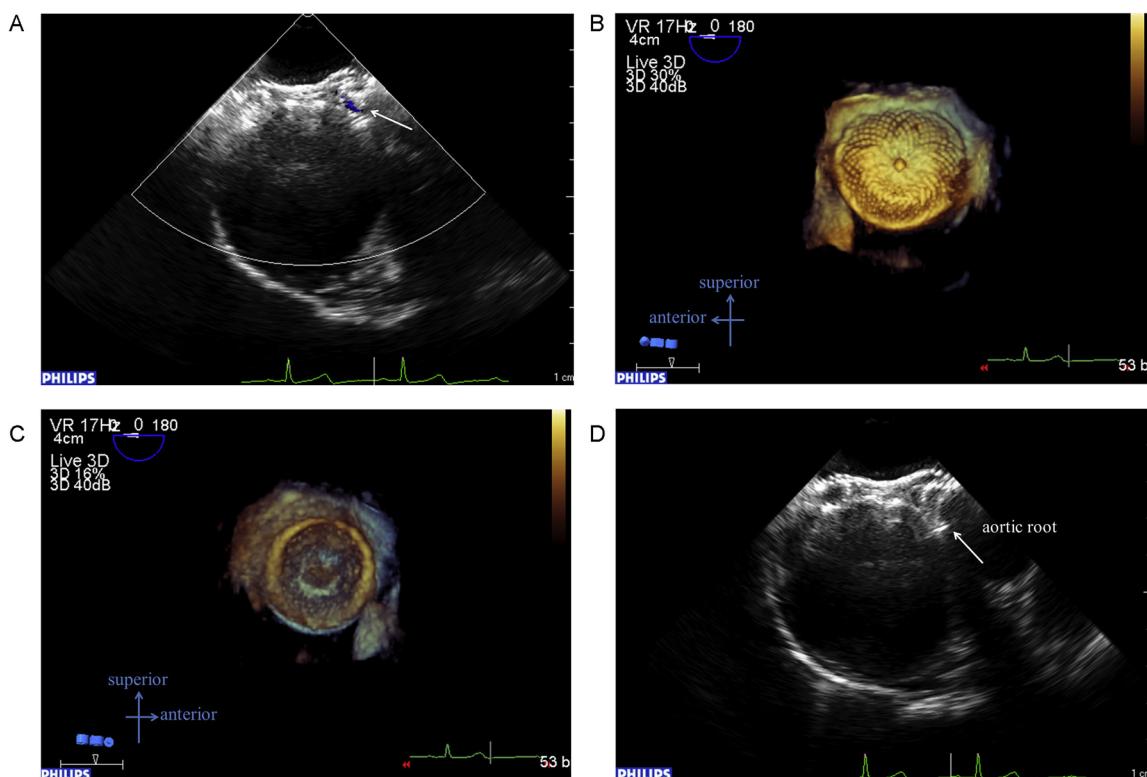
Deployed images of the device. (A) The image shows the device deployed in an appropriate position against the atrial septum. A small residual shunt from the aortic side is demonstrated in a color Doppler image (arrow). (B and C) Three-dimensional transesophageal echocardiography (TEE) shows the device properly deployed against the atrial septum visualized in views from the left atrium (B) and from the right atrium (C). (D) TEE image of the deployed device. Right atrial side of the device is tightly impinging on the aortic root (arrow).
